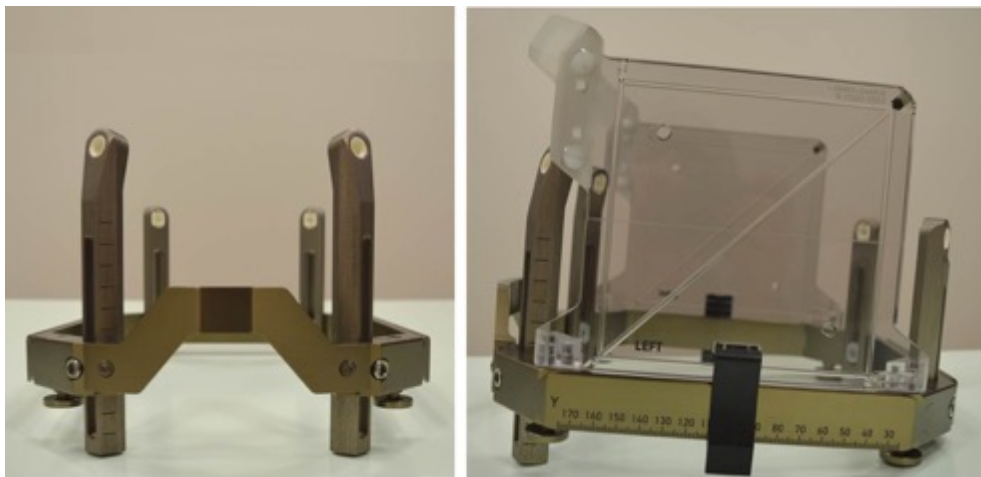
Leksell stereotactic coordinate frame G. Left: Frame assembled with the curved front piece in the upwards position, angled anterior insulated posts and medium straight insulated posts posteriorly. Right: Lateral view of the Leksell G frame with the MRI fiducial indicator box attached.
